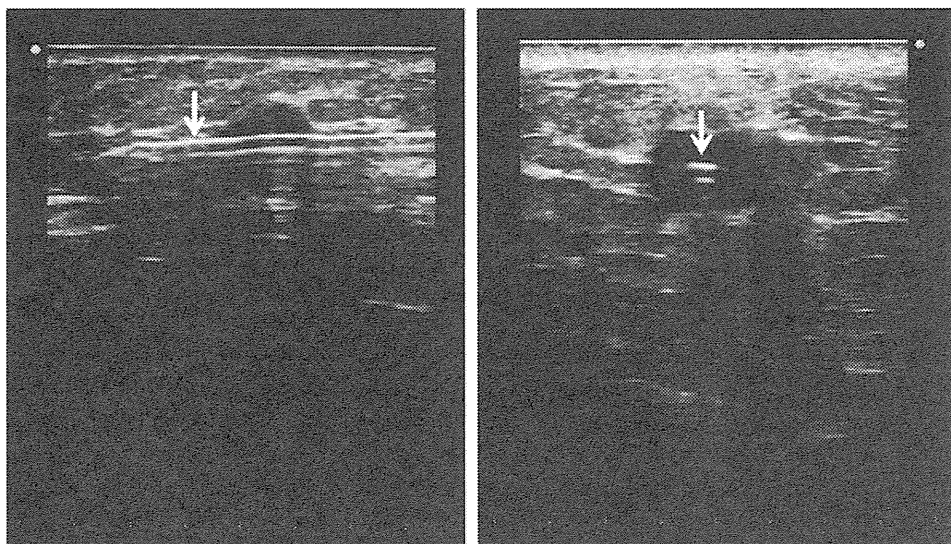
The needle (*arrows*) penetrating at the center of the tumor as confirmed by two-dimensional ultrasound. *Left* The tip of the needle was placed outside of the tumor approximately 5 mm from the edge of the tumor
